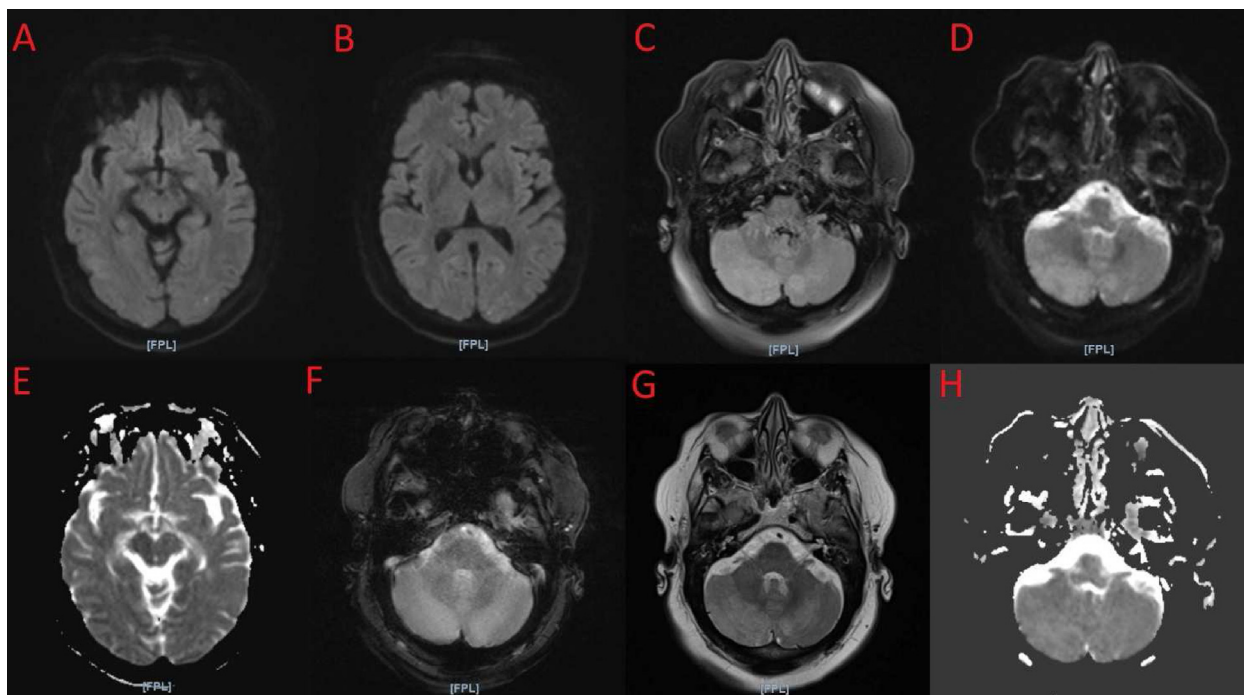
Magnetic resonance imaging (MRI) on the day of presentation. A, B: Diffusion-weighted images with showing punctate hyperintense lesions in bilateral occipital lobes. C: Fluid-attenuated inversion recovery (FLAIR) showing abnormal hyperintensities in bilateral cerebellum, right greater than left. D: Diffusion-weighted images of the cerebellum not showing any hyperintense abnormalities. E: Apparent diffusion coefficient (ADC) image corresponding to image A showing hypointense punctate lesions. F: Gradient echo (GRE) image with no evidence of hemorrhage. G: T2-weighted image showing findings similar to the FLAIR image. H: ADC image of the cerebellum not showing any hypointense abnormalities.
